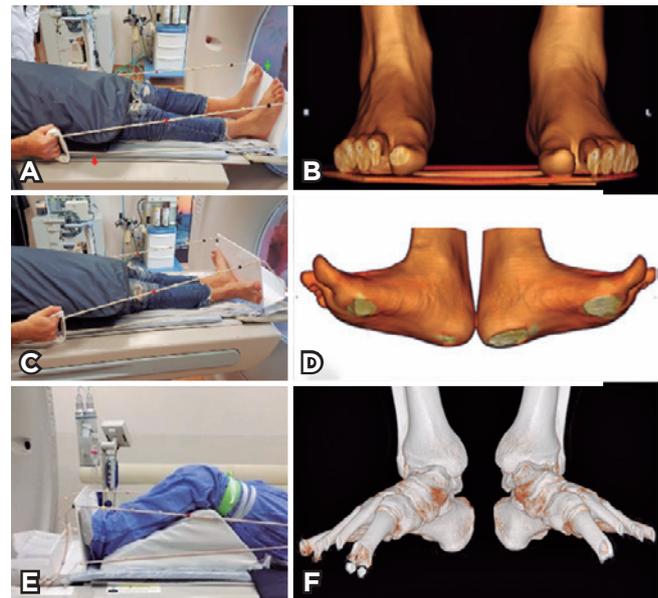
Position of feet during the CT examination. Photograph of a patient undergoing CT in the neutral position (A). A three-dimensional skin surface reconstruction CT image showing the feet in the neutral position (B). Photograph of a patient undergoing CT with ankle stress maneuvers and extended knees (C). A three-dimensional skin surface reconstruction CT image showing the feet with stress maneuvers and extended knees (D). Photograph of a patient undergoing CT with ankle stress maneuvers and semi-flexed knees (E). A three-dimensional bone reconstruction CT image showing the feet with stress maneuvers and semi-flexed knees (F).
